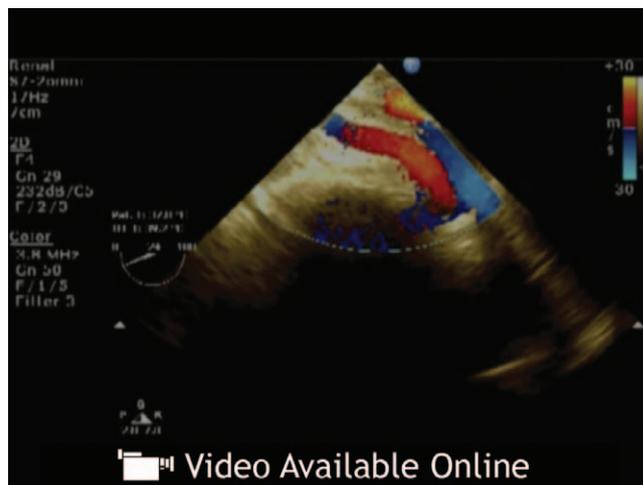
A, The figure demonstrates the anatomical relationships of the left kidney, aorta, inferior vena cava (IVC), and the vertebral body. The vertebral body appears as a hypoechoic transversely oriented oval structure. The left kidney is seen left and lateral to the vertebral body, aorta just anterior, and the IVC anterolateral to it. The vertebral body creates an acoustic shadow. The 2 round structures at this depth (aorta and IVC) can be differentiated by: (1) their relative position, and (2) Doppler tracing (pulsed-wave Doppler). B, Lateral to the convex-shaped left kidney is the concave inner border of the spleen. The 2 organs have different echogenicity: the kidney has a brightly echogenic central zone (pelvis) in contrast to the hypoechoic peripheral cortex, whereas the spleen is uniformly hypoechoic. A modest right turn of the probe from the view seen in (A) may help obtain the view seen in (B).
